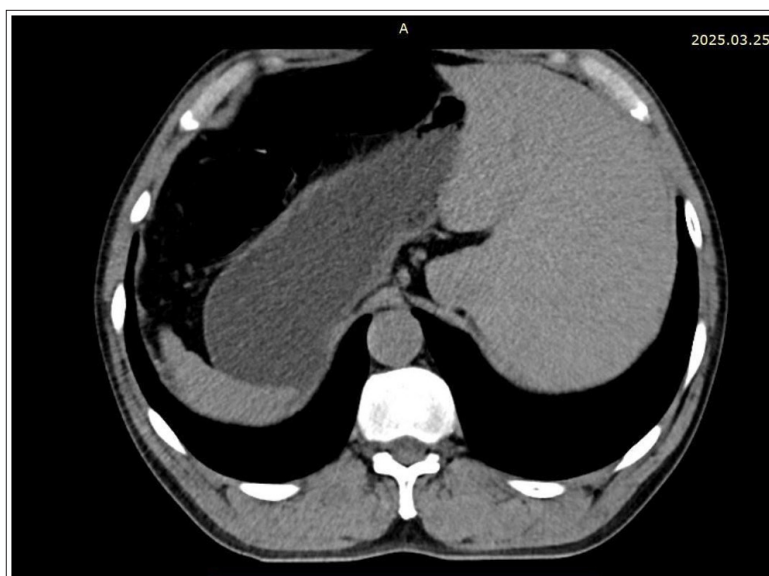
Contrast Enhanced Computed Tomography Picture.
